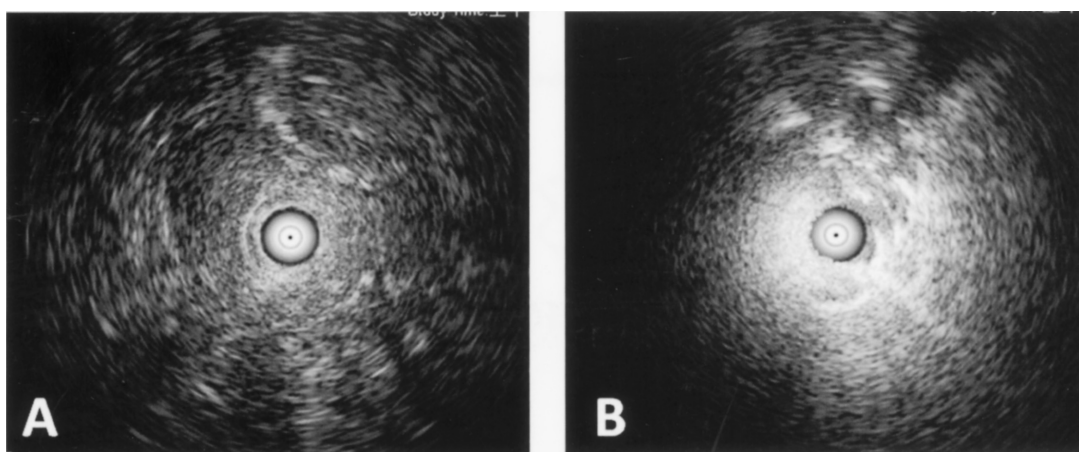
Endobronchial ultrasonography. (A) Picture from the right middle lung mass showing heterogeneity, without concentric circles and with a continuous hyperechoic margin; (B) Picture of the left upper lung mass showing homogeneity, with hyperechoic dots, a discontinuous hyperechoic margin, and concentric circles.
